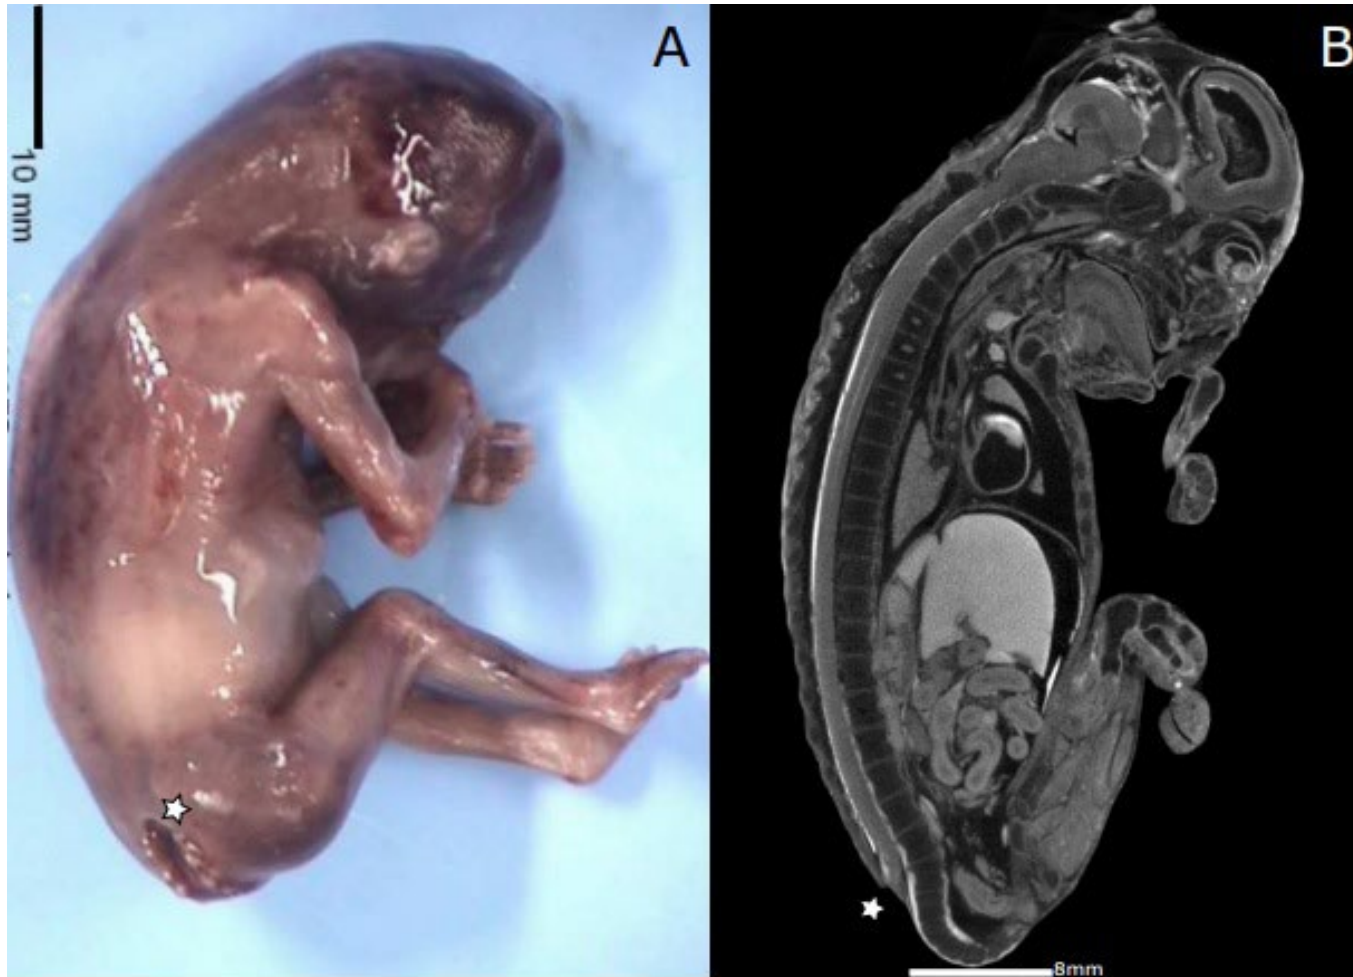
Micro CT examination of sacral NTD, external examination (star), initially overlooked on the micro CT data (B).
